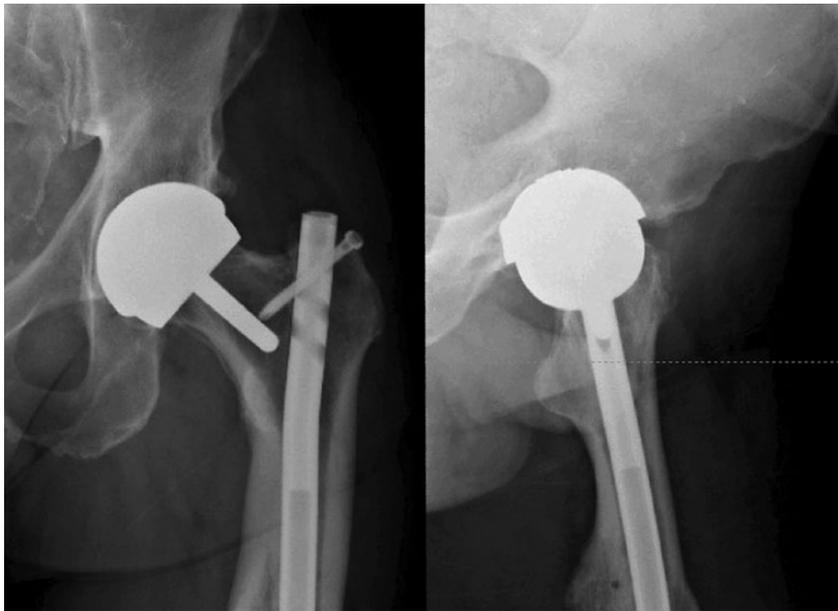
Radiographs of patient with femoral intramedullary nailing performed for malunion of a fracture to the femoral diaphysis, who has undergone hip resurfacing for hip arthrosis.
